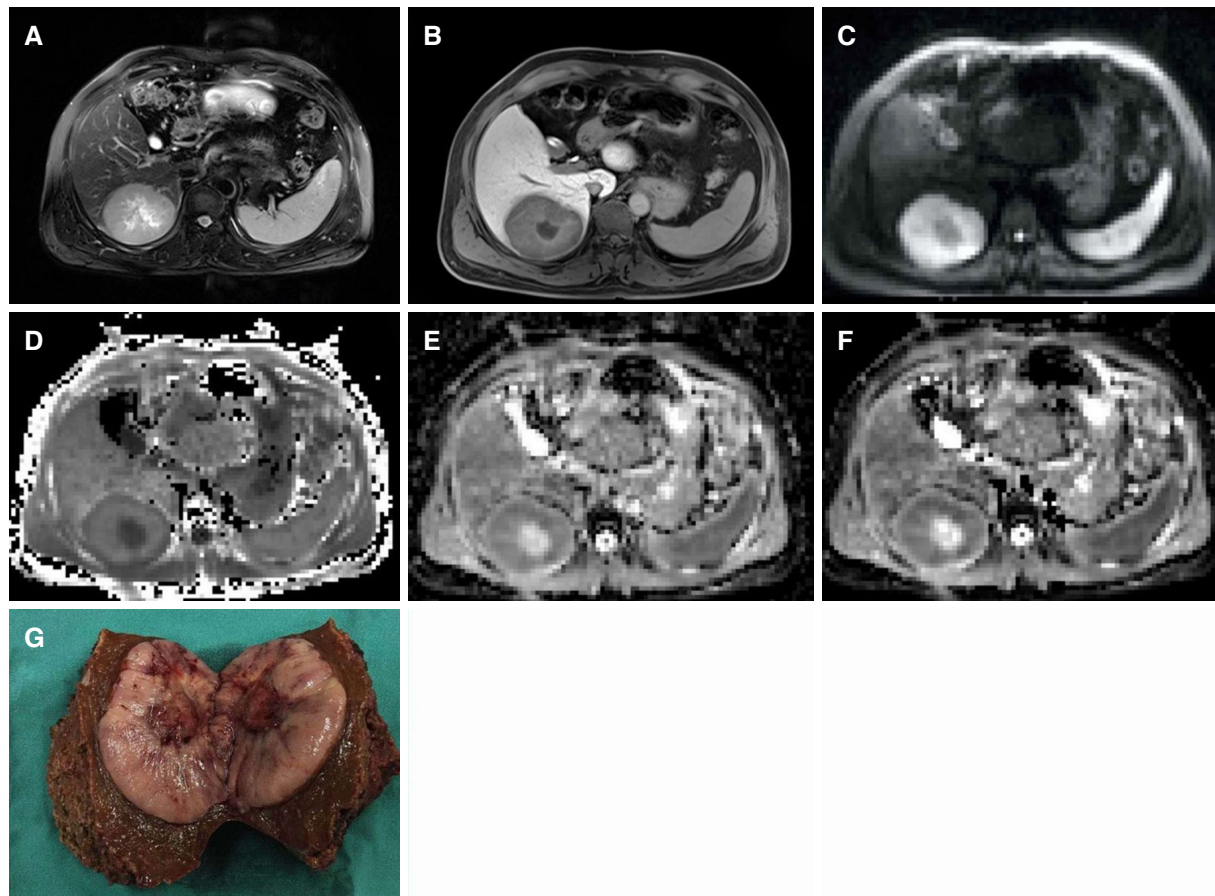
A 48-year-old male with a pathologically confirmed HCC with MVI. A 7.8 cm × 6.0 cm tumor in the right posterior hepatic section shows slight hyperintensity on T2-weighted image (A), hypo-intensity relative to the surrounding liver parenchyma in hepatobiliary phase (B), and restricted diffusion on the DWI with a b-value of 700 s/mm² (C). MK map (D) shows higher signal intensity of tumor compared with that of background liver parenchyma. ADC (E) and MD (F) maps show lower signal intensity compared with that of liver parenchyma. The calculated mean values of MK, ADC, and MD for the tumor were 0.99, 1.10×10^{-3} mm²/s, and 1.28 mm²/s, respectively. The pathological results after tumor resection demonstrated HCC [Edmondson-Steiner (III) with positive MVI (G)]. HCC: hepatocellular carcinoma; DWI: diffusion-weighted imaging; ADC: apparent diffusion coefficient; MD: mean diffusion; MK: mean apparent kurtosis coefficient
